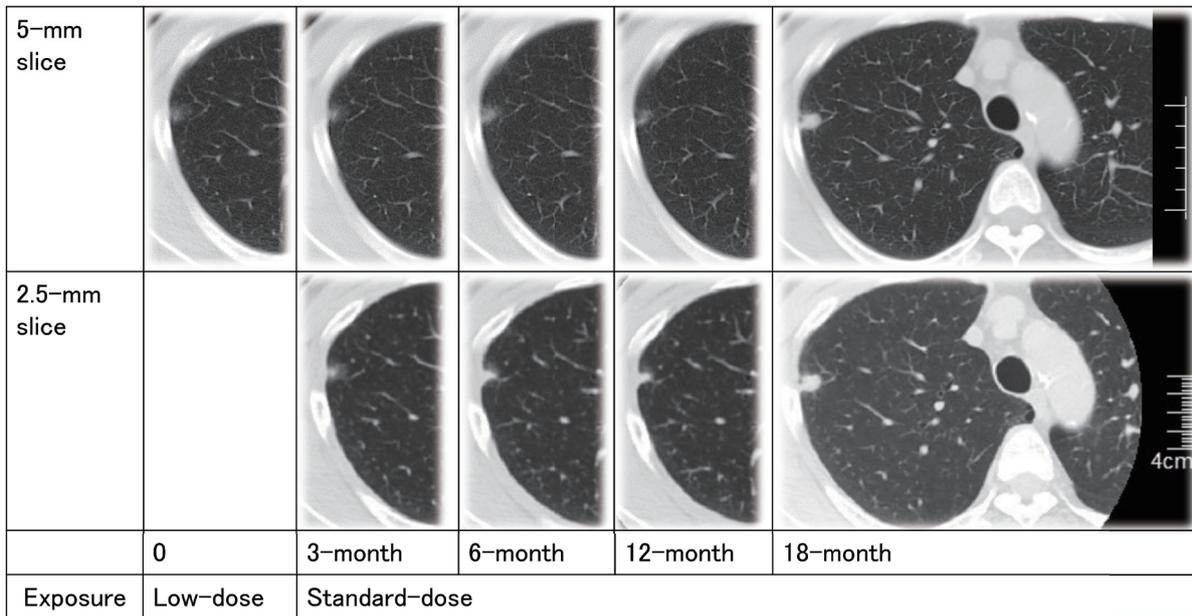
Computed Tomography (CT) Findings
